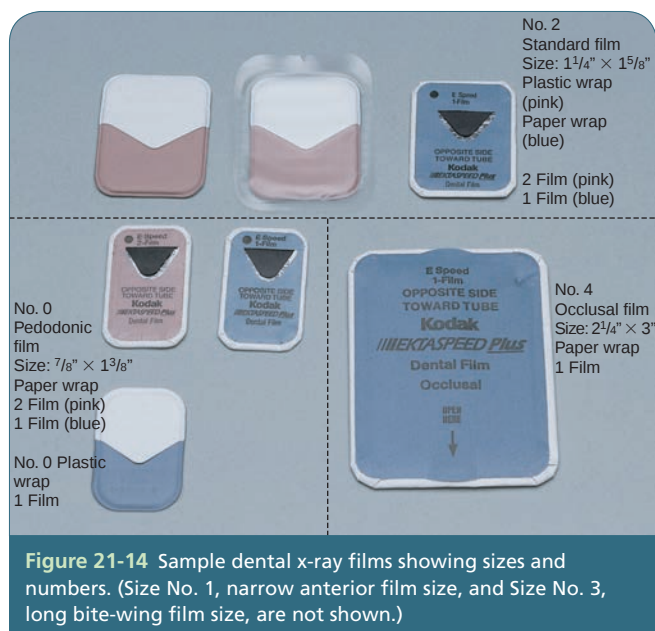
Sample dental x-ray films showing sizes and numbers. (Size No. 1, narrow anterior film size, and Size No. 3, long bite-wing film size, are not shown.)
